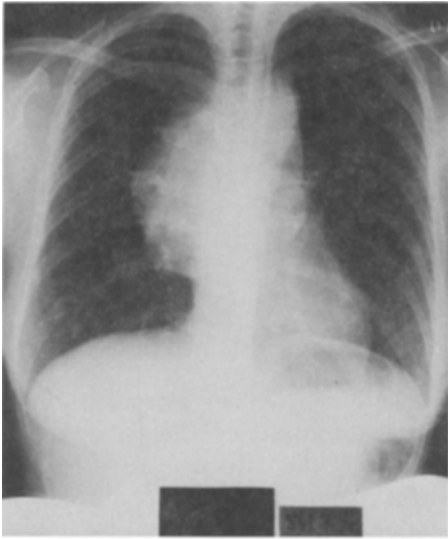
Chest roentgenogram showing a large mediastinal tumor.
